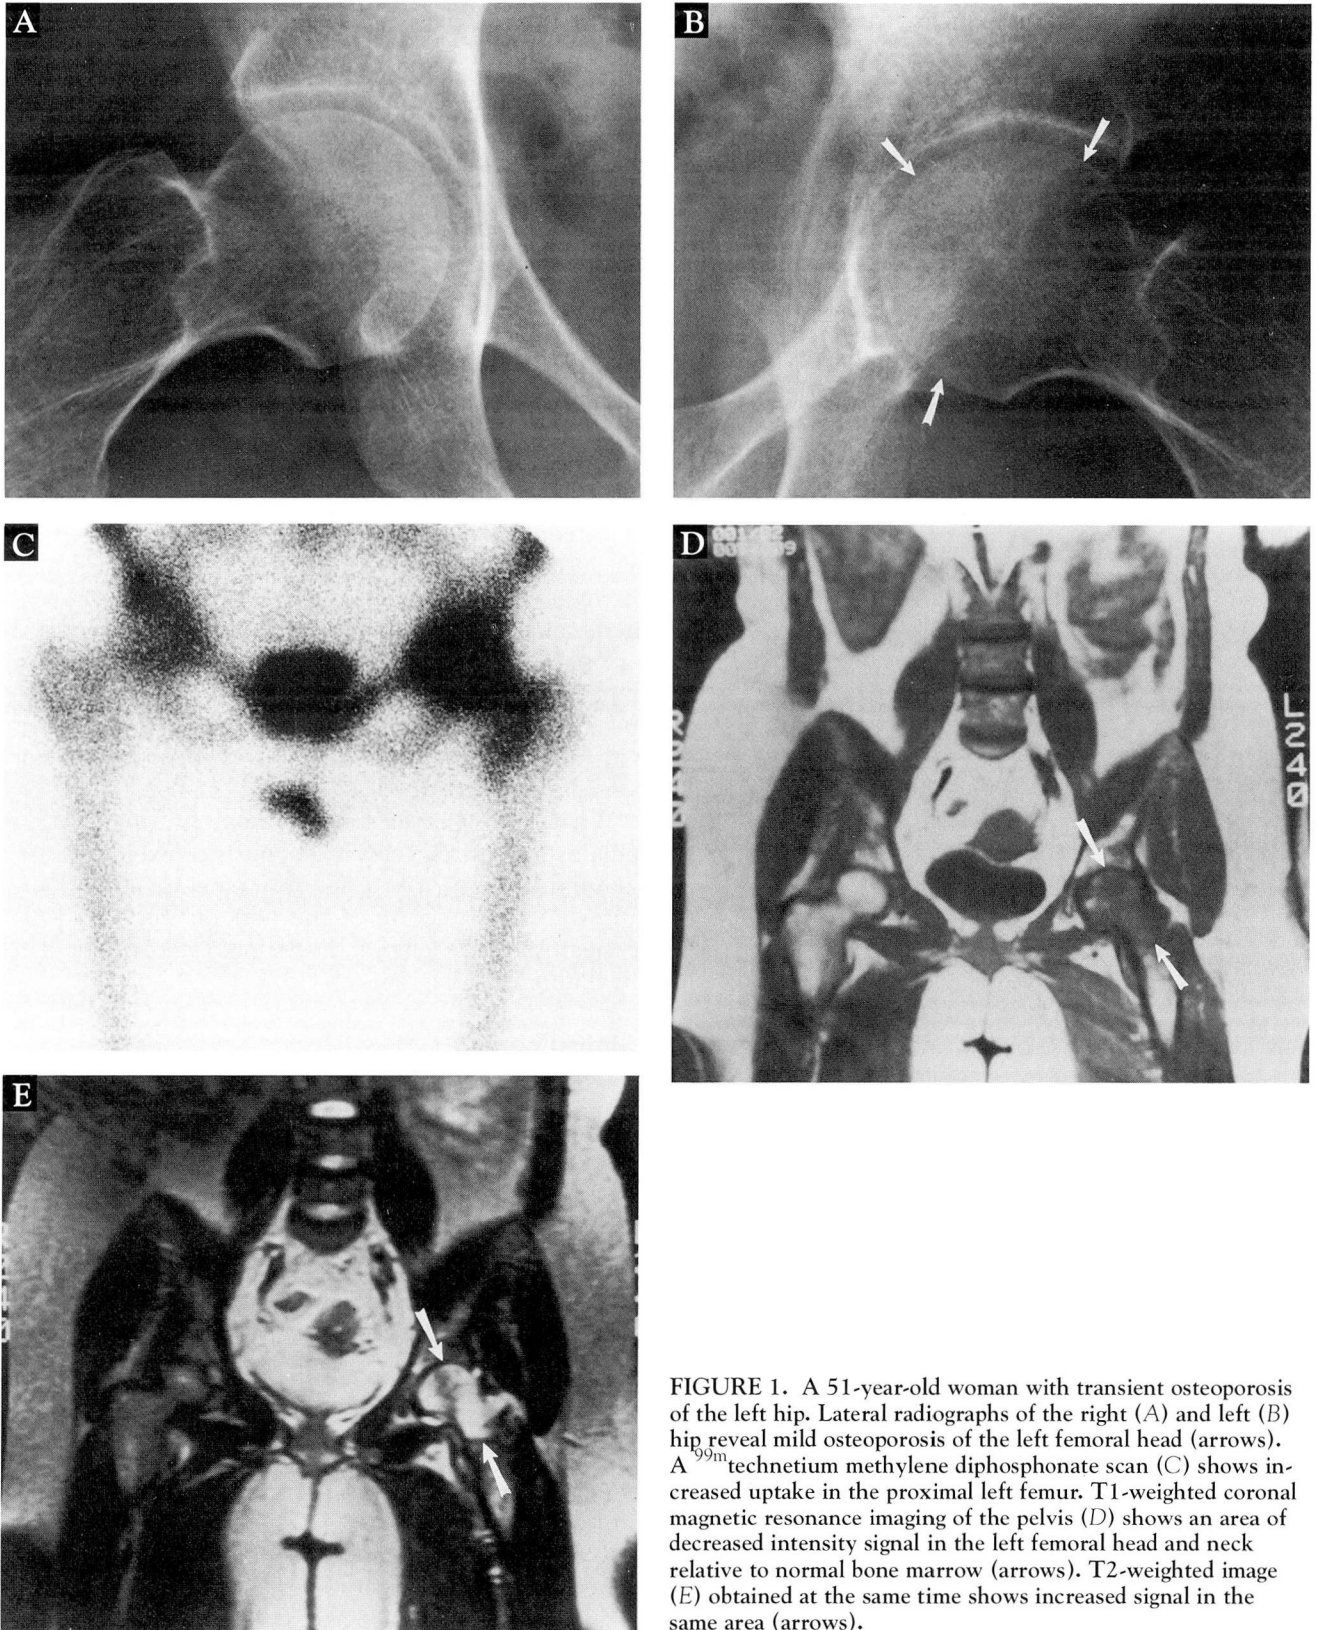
A 51-year-old woman with transient osteoporosis of the left hip. Lateral radiographs of the right (A) and left (B) hip reveal mild osteoporosis of the left femoral head (arrows). A ^{99m}Tc methylene diphosphonate scan (C) shows increased uptake in the proximal left femur. T1-weighted coronal magnetic resonance imaging of the pelvis (D) shows an area of decreased intensity signal in the left femoral head and neck relative to normal bone marrow (arrows). T2-weighted image (E) obtained at the same time shows increased signal in the same area (arrows).
